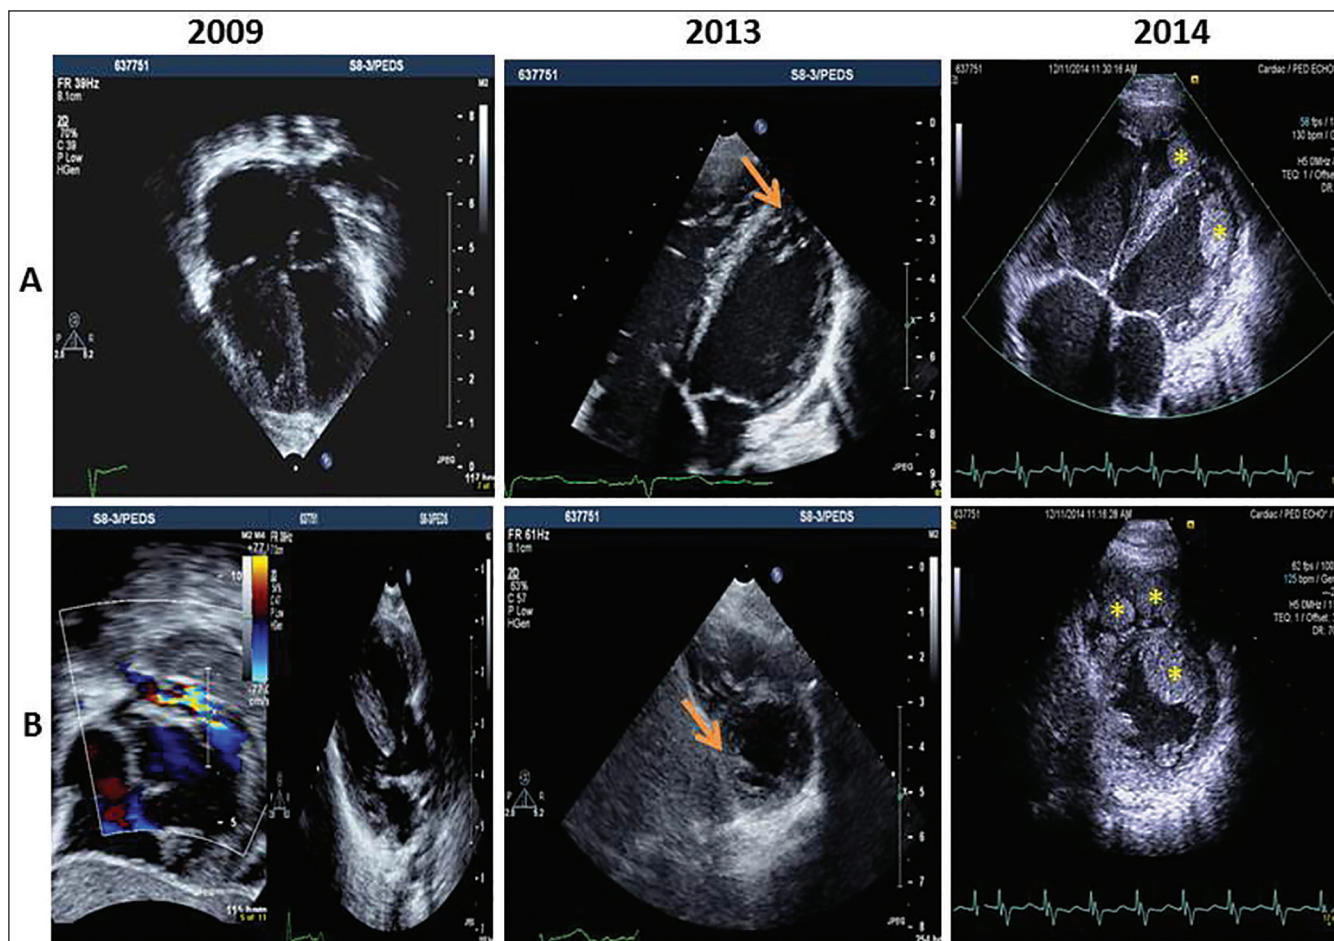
2009 Panel A: Apical four-chamber view at the baseline evaluation showing no hypertrabeculated left ventricle (LV). 2009 Panel B: Subcostal view and parasternal long axis view showing the typical tetralogy of Fallot features, anterocephalic deviation of the infundibular septum, right ventricular outflow tract obstruction, large ventricular septum defect, overriding aorta. 2013 Panel A: Apical four chamber view showing the presence of hypertrabeculated left ventricular apex (arrow); 2013 Panel B: Parasternal short axis view showing hypertrabeculated LV (arrow). 2014 Panel A: Apical four chamber view showing a clot in the dilated right ventricle (star) and a large clot in the hypertrabeculated LV (star); 2014 Panel B: Parasternal short axis showing multiple clots (stars) in the right ventricle and the hypertrabeculated LV (star)
